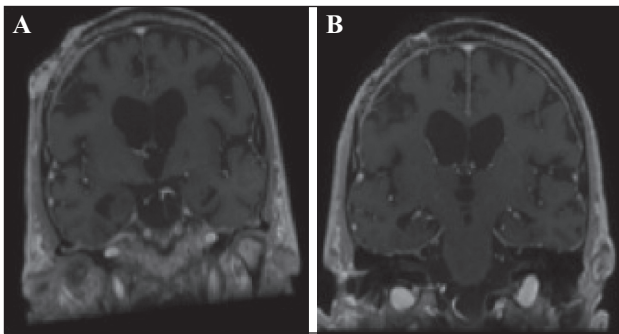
Magnetic resonance imaging of Patient 4 before treatment (A) showing bone and leptomeningeal invasion, and three months after treatment (B) showing an impressive partial response.
